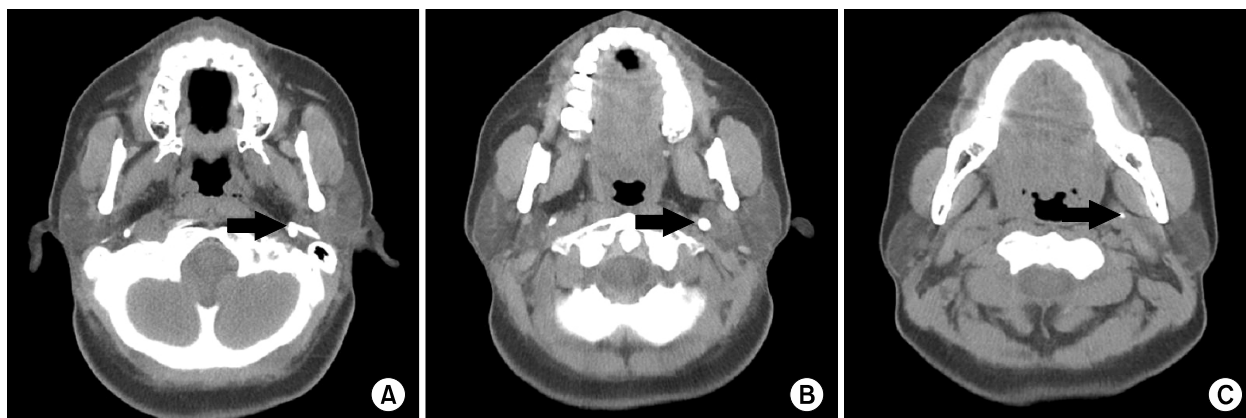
Axial CT view shows elongated styloid process at left side (black arrows). (A) Origin, (B) Midportion, (C) Distal portion.
